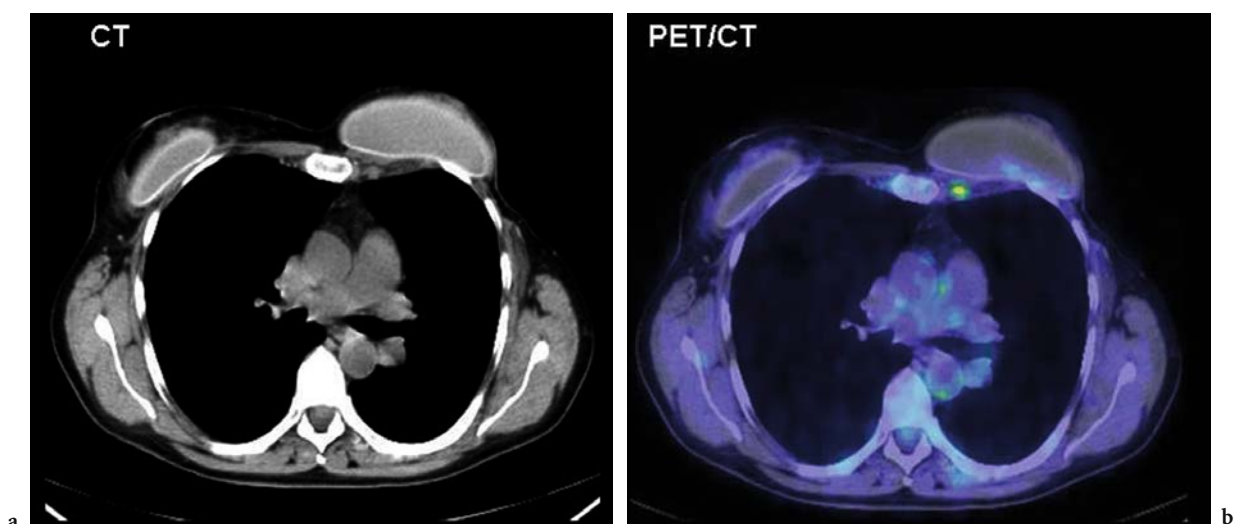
Patient with breast cancer: a metastasis in a lymph node of the left internal mammary chain was detected by PET/CT
